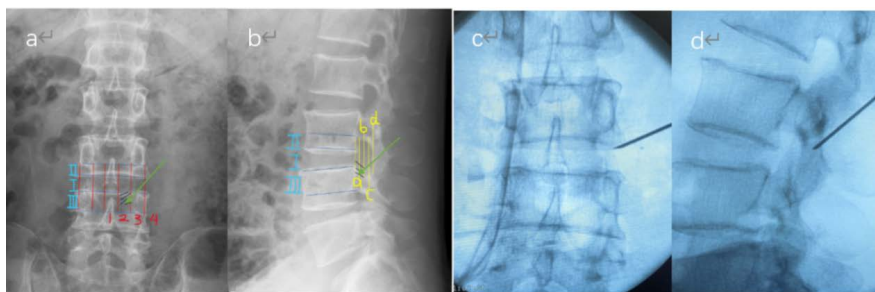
Presents preoperative X-ray images of a 44-year-old male patient with a left-sided L3/L4 disc herniation, showing the localization area (marked by black diagonal lines) and the direction of needle insertion (indicated by green arrows) in images (a) and (b); intraoperative fluoroscopic images of the needle insertion are shown in (c) and (d).
